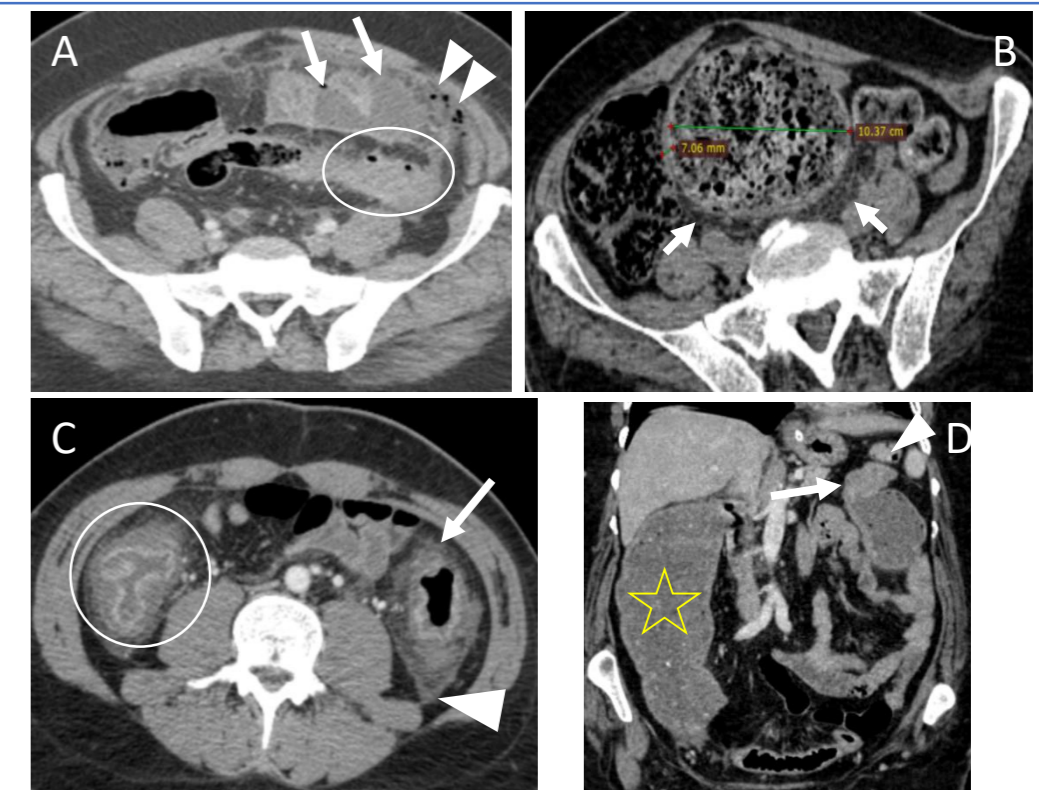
Various CT findings of acute colorectal lesions. (A) Axial contrast enhanced CT (CECT) showed complicated acute sigmoid diverticulitis with abscess formation (arrows) and pneumoperitoneum (arrowheads). Note the thickened sigmoid colon with diverticula and surrounded by fat stranding (circle). (B) Axial non contrast CT in a case of SC due to faecal impaction showed dilated rectum and sigmoid colon with faecaloma and circumferential segmental thickening of the rectum and sigmoid colon with surrounding fat stranding (arrow). (C) Axial CECT in a case of PMC showed pancolitis noted in the form of nodular thickening and hyperenhancing mucosal lining (circle), fat stranding (arrow) and free fluid collection (arrowhead). (D) coronal CECT in a case of splenic flexure adenocarcinoma complicated with LBO showed suspected enhanced irregular circumferential focal wall thickening noted at splenic flexure (arrow) with proximally dilated colon (asterisk) and distally collapsed colon (arrowhead in D).
